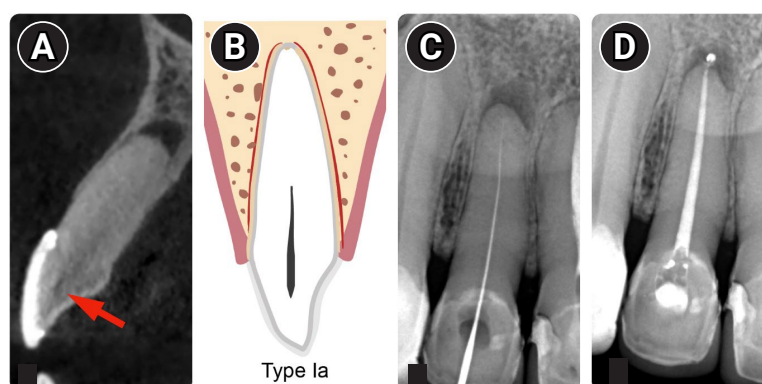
Characteristics of Type Ia root canal classification. (A) Tomographic image. The red arrow indicates the target point (start of the canal) without any change from its original position. It is clearly visible in the sagittal cone-beam computed tomography view. The root canal disappears at the start of the cervical third of the root. (B) Type Ia classification scheme. (C) Initial root canal negotiation with a file to determine the temporary working length. (D) Filled canal.
